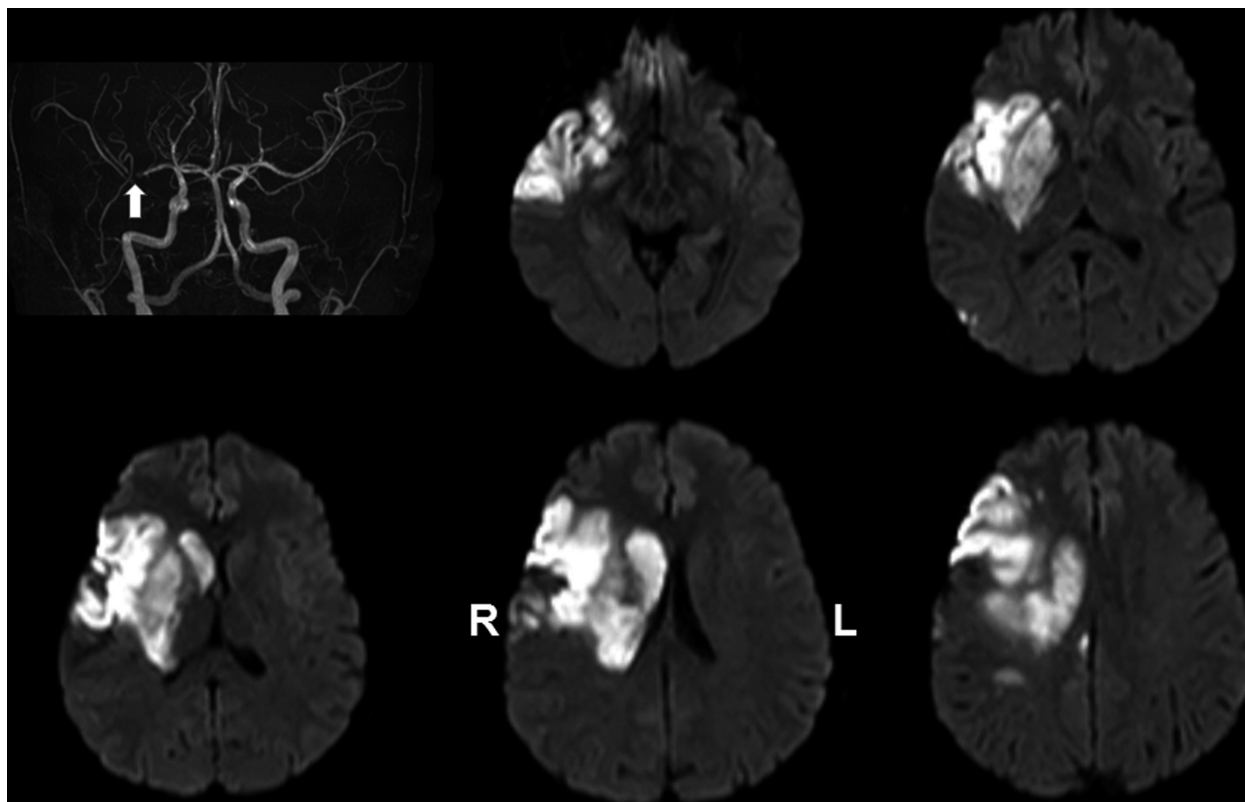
Patient's magnetic resonance imaging scan on hospital day #2 showing right middle cerebral artery occlusion (arrow) and infarction of the right temporal and frontal lobes, insula, basal ganglia, internal capsule, and corona radiata.
